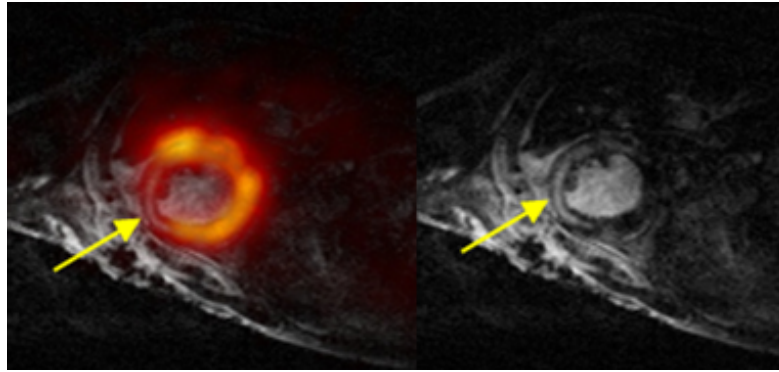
Co-registered PET/MR images showing myocardial infarction as hyperintense region on LGE MRI taken in diastole (left) and corresponding decreased uptake region in ^{18}F -FDG 3DRP PET image (right), indicated by yellow arrow.
